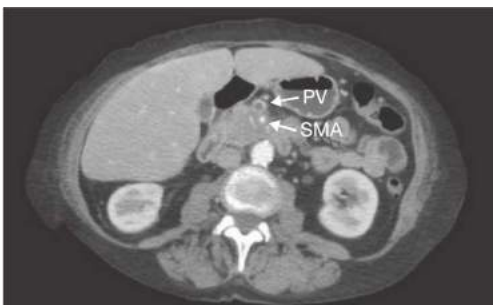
• CT of an unresectable/locally advanced pancreatic cancer. The lesion has encircled the SMA. PV, portal vein.
